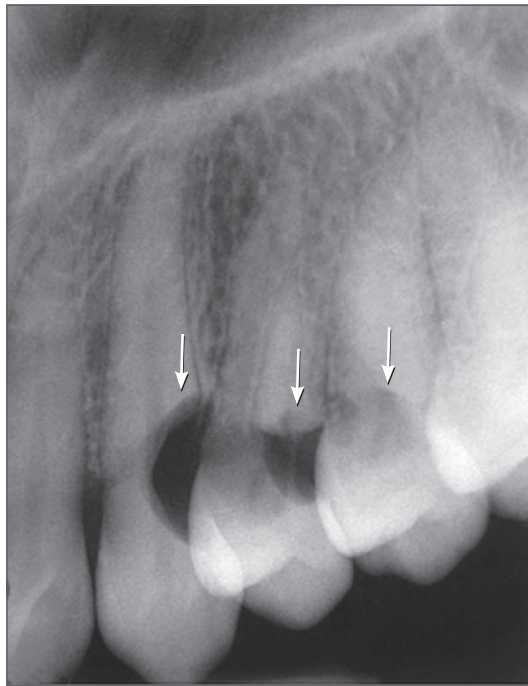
Initial periapical radiograph; note overlapping (arrows).
